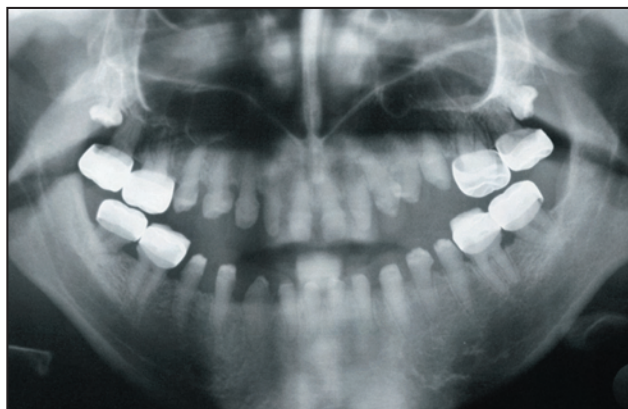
Panoramic radiograph at the end of the initial treatment.
